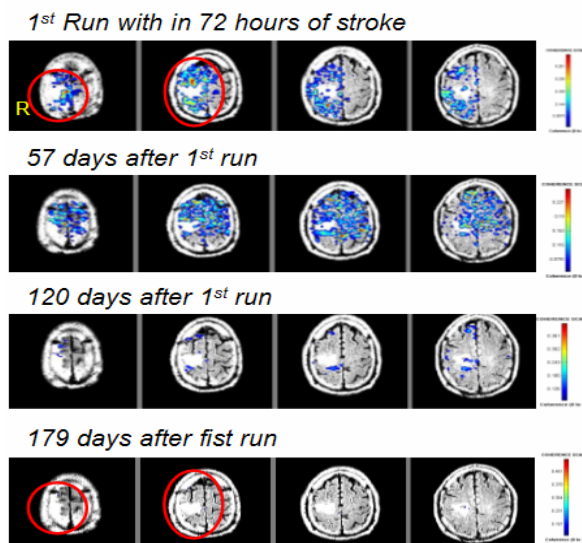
MRI shows localization of activated cortex around the stroke lesion in the right superior parietal area for one patient. MEG Coherence analysis from spontaneous brain activity is shown on the MRI. Circles indicate cortical areas where significant changes in Delta coherent activity occurred. This patient had a good outcome.
